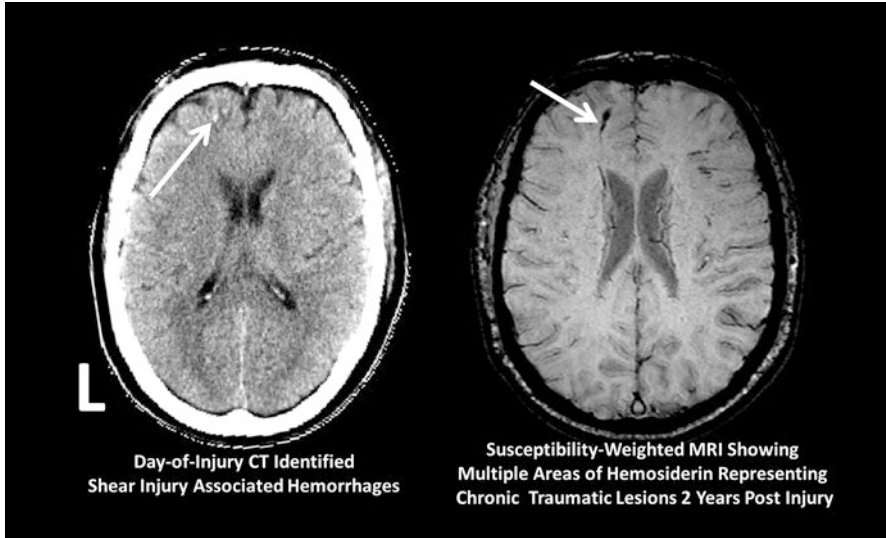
(Left) Day-of-injury (DOI) CT with a solitary petechial hemorrhage in the frontal lobe. (Right) Contrast susceptibility-weighted imaging (SWI) shows that the hemorrhagic lesion was larger than that detected by the CT. Because the images in Fig. 25.5 are presented in 3-D, these axial images show left on the viewer's left
